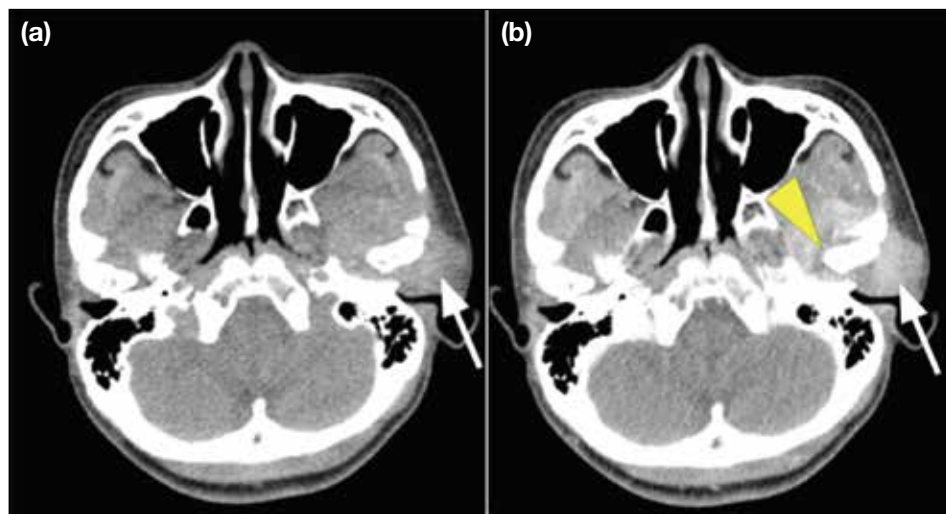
(a) Unenhanced and (b) post-contrast axial computed tomography images in soft tissue window show an enhancing tumour (arrows) at the preauricular region centring around the left temporomandibular joint. A rim of non-enhancing joint effusion is seen (arrowhead).
